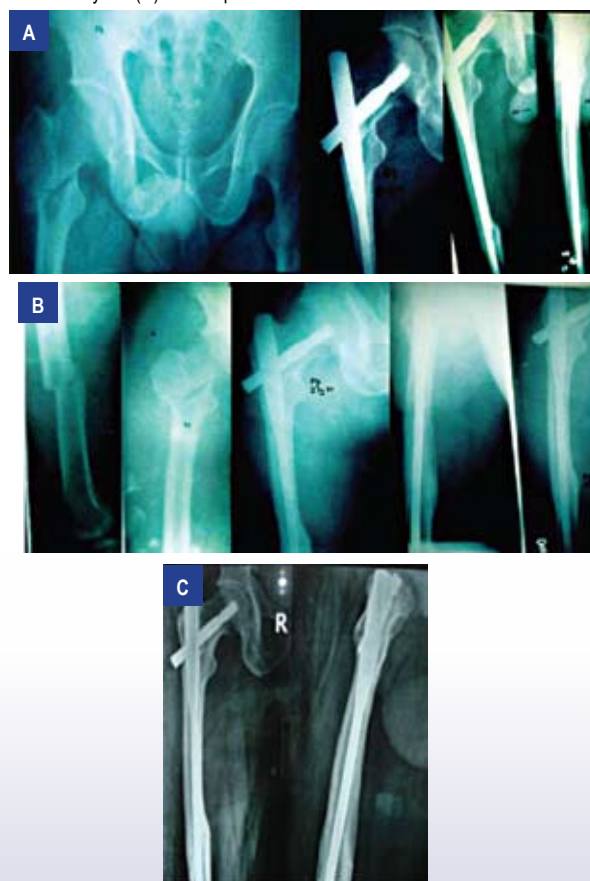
A-Preoperative X-ray showing Ipsilateral subcapital fracture neck femur with shaft fracture treated by Gamma nail. B-Post operative X-ray showing excellent union of combination fracture treated by Gamma nail - 8 yrs follow up
